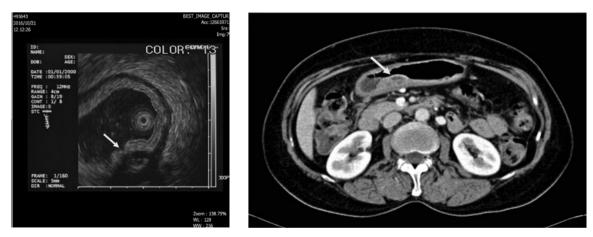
(Left): The endoscopic ultrasonogram showed a $2.7 \times 1.2 \text{ cm}$ tumor, arising from 2nd to 4rd layer with mixed echo pattern (arrow). (right): The abdominal CT showed a flat-ovoid shape submucosal tumor ($2.5 \times 1.5 \text{ cm}$) in the posterior wall of gastric antrum with intraluminal growth pattern, an ill-defined tubular-like hypoenchanced area in anterior part of tumor (arrow).
